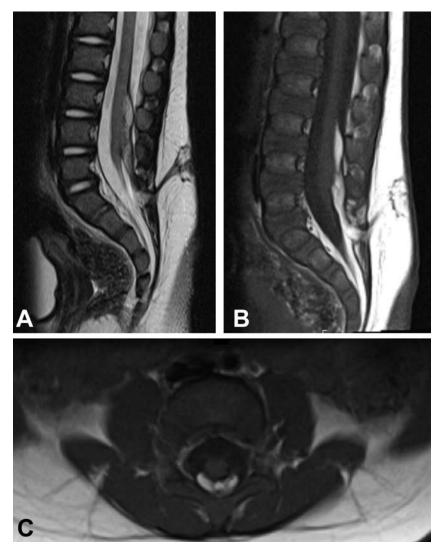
Spinal MR imaging of a 5-month-old patient with a dermal sinus tract and intradural lipoma. A: Sagittal T2-weighted sequence demonstrating the conus medullaris at L-5 and the dermal sinus tract. B: Sagittal T1-weighted sequence shows the intradural lipoma and connection to the dermal sinus tract at the S1–2 level. The intradural lipoma is seen extending from L-3 to S-2. C: Axial T1-weighted sequence demonstrates the intradural lipoma.
